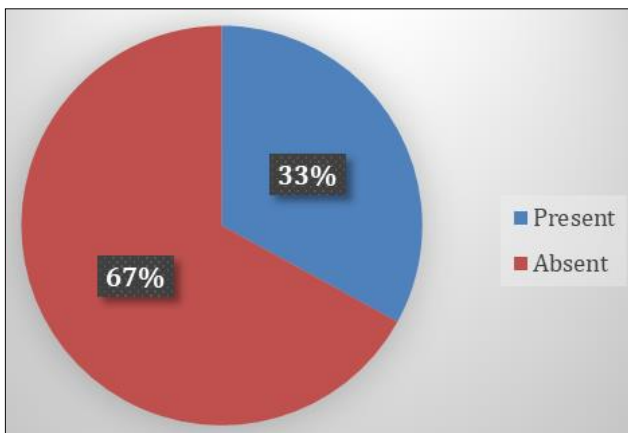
No. of patients with osseous/osteochondral changes on MRI
